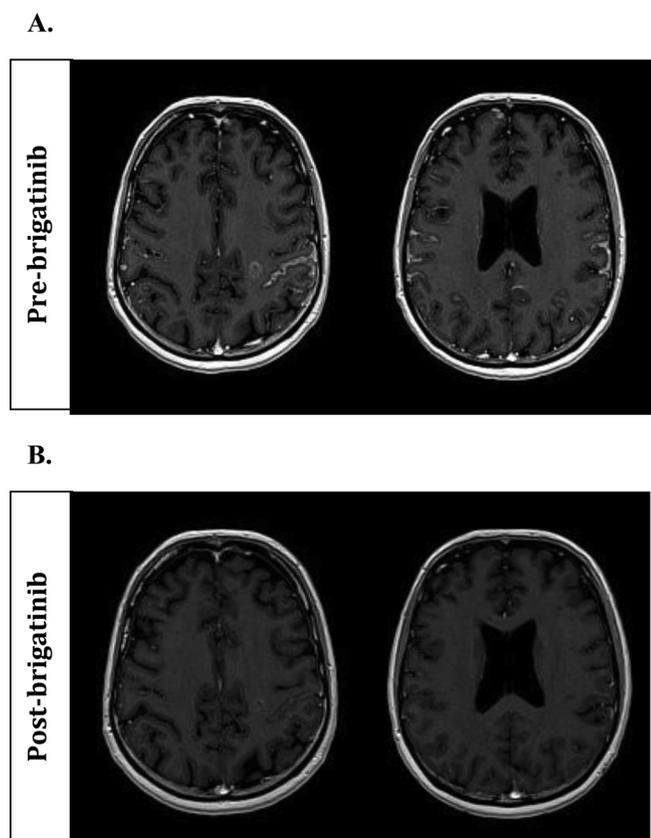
Axial magnetic resonance imaging (MRI) of the brain. A. Before brigatinib, in January 2017, showing multiple intra-axial brain metastases associated with leptomeningeal enhancement. B. After 2 months of brigatinib, patient showing partial intracranial response with marked regression of leptomeningeal and parenchymal enhancement.
